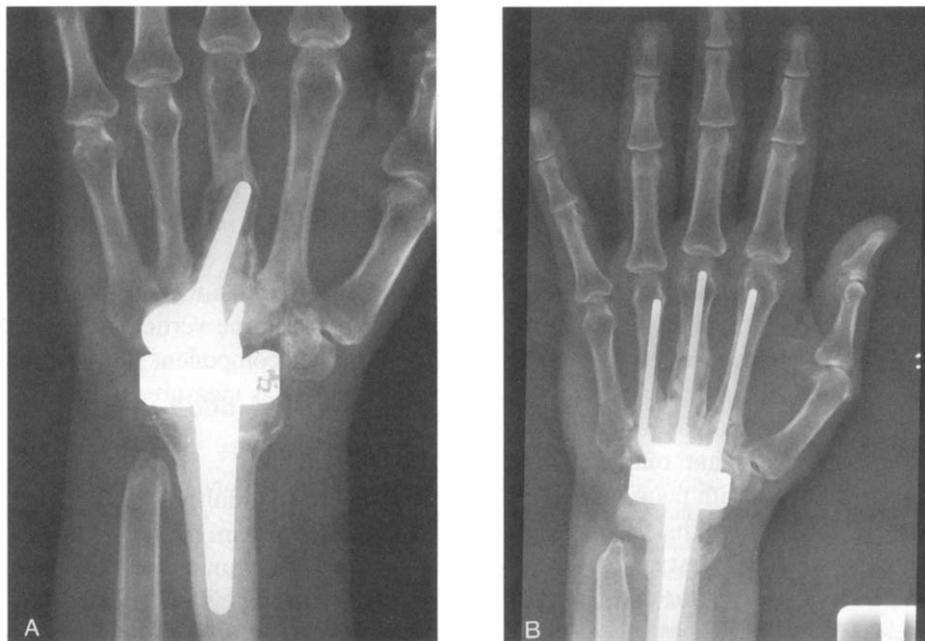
A 37-year-old woman with rheumatoid arthritis. (A) Anteroposterior radiograph 2 years after total-wrist arthroplasty, with loosening and migration of distal component. (B) Anteroposterior radiograph 4.8 years after revision total-wrist arthroplasty using custom three-pronged distal component.
